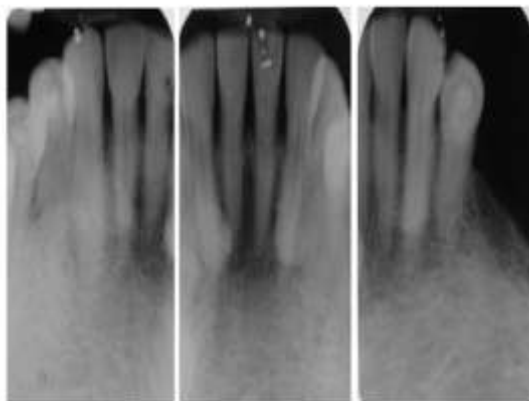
Periapical radiographic series of the lower arch. The level of the bone crest is appreciated.
